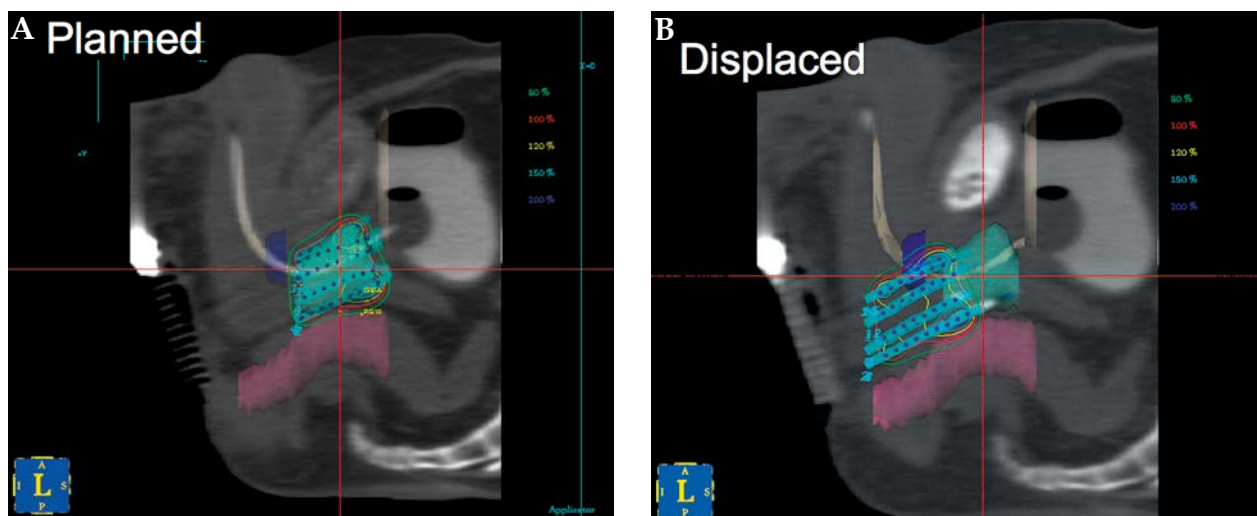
For a CT planned technique, catheters are inserted under TRUS guidance and the template fixed to the perineum. Acquisition of CT images for planning usually requires transfer of patient and change in leg position. Following plan optimization and prior to treatment delivery, repeat imaging is required to correct for any catheter displacement
